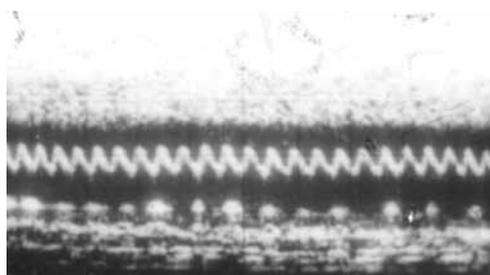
World's first fetal echocardiogram (courtesy XF Wang).
